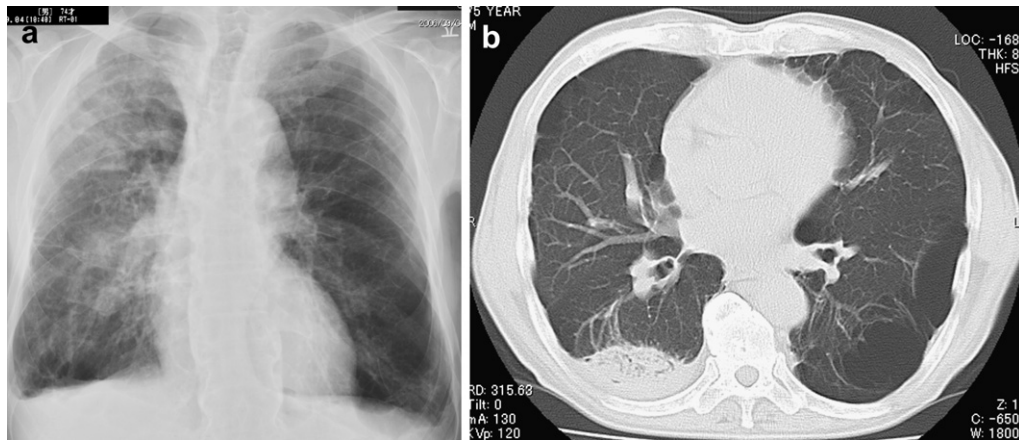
(a) Plain chest radiograph demonstrated hyperlucent and fibrous lung with right lung field mass. (b) Chest computed tomography showed bilateral bullous lung with fibrosis, and the right B⁶ mass with crescent sign.
